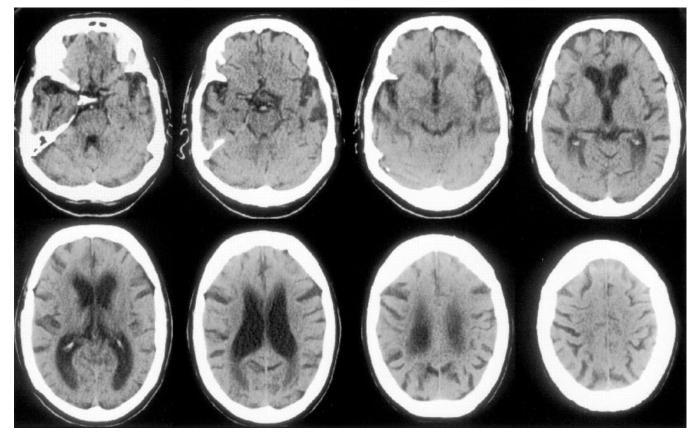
CT scan of Subject III-22 shows a moderate degree of atrophy.
